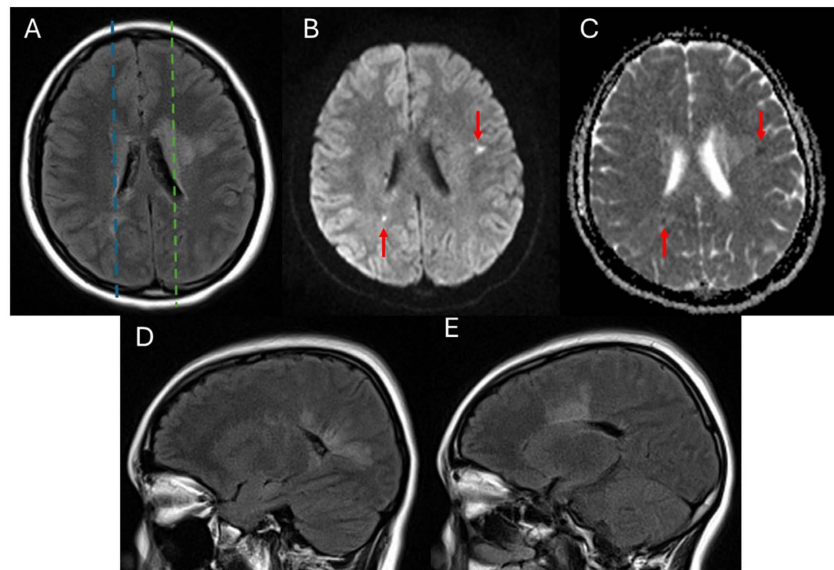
Abnormal T2 hyperintensities and diffusion restriction on MRI brain. ((A) - (C), Axial slices of T2 FLAIR (A), diffusion-weighted imaging (B), and apparent diffusion coefficient (C) at the same level, showing small areas of diffusion restriction (red arrows) within the larger areas of T2 hyperintensities. (D)-(E), Sagittal T2 FLAIR at the level of the blue dotted line (D) and green dotted line (E) in A, further demonstrating the periventricular distribution of T2 hyperintensities.
